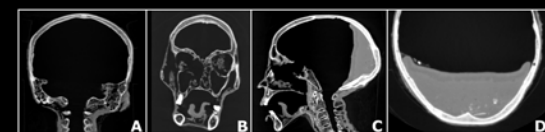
CT scan of Pa-Ib, showing (A) the absence of brain and dura, (B) the damaged orbit and ethmoid air cells, (C) the damaged sphenoid, and (D) resin and bone fragments in posterior cranium.
